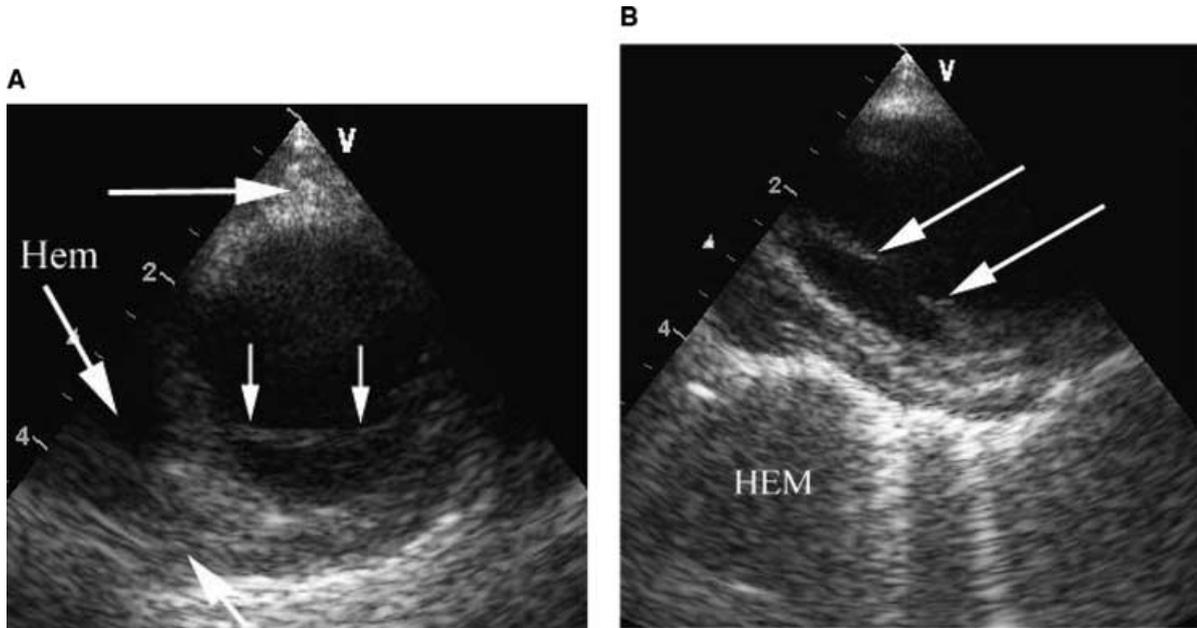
Transesophageal echocardiogram (TEE) at the level of the proximal descending thoracic aorta (similar level as the CT in Figure 1) at the aortic isthmus. A. Horizontal plane imaging demonstrates an intima-media flap (vertical arrows). Mediastinal hematoma is noted surrounding the aorta (diagonal arrows) and between the esophagus and aorta (horizontal arrow). This image correlates with the CT of Figure 1B. B. At 105° the intima-media flap (diagonal arrows) appears “torn,” an appearance similar to the CT image of Figure 1A.
